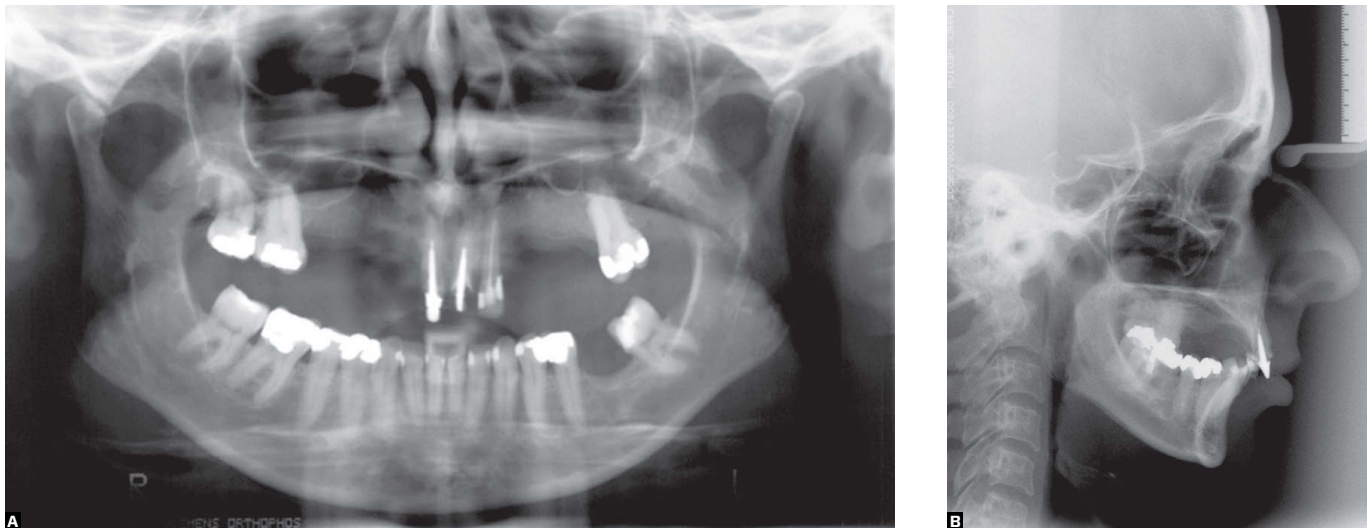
Initial radiographs.
